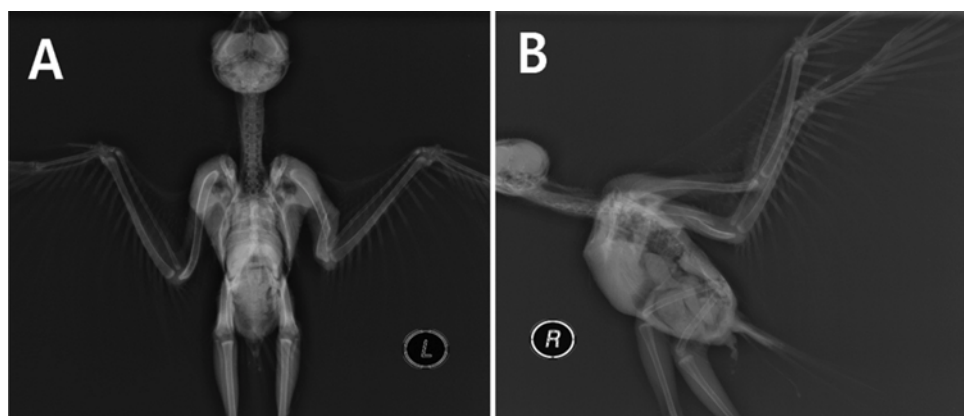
Ventrodorsal (A) and right lateral (B) radiographs revealing left humerus fracture.
